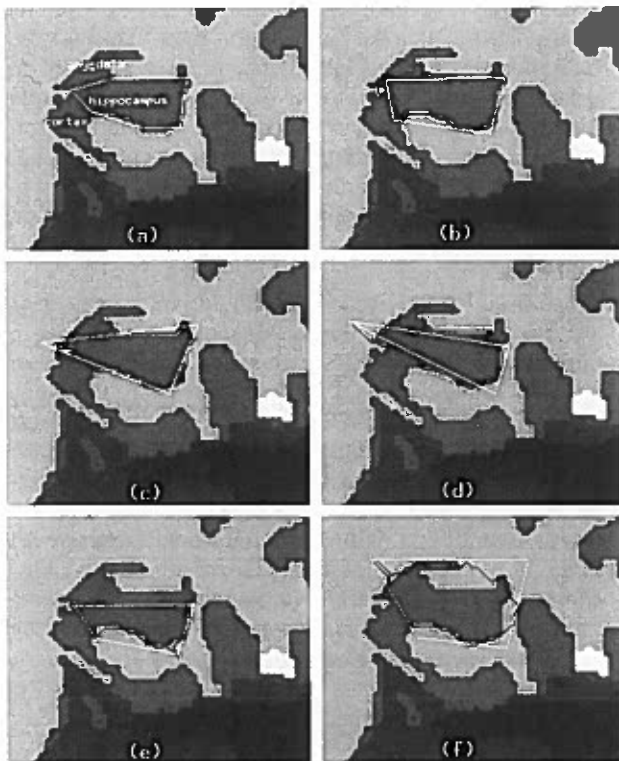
Results of contour segmentation on a single slice of segmented MRI data with various initial contours. Initial contours are shown in white, Final contours are shown in black.
